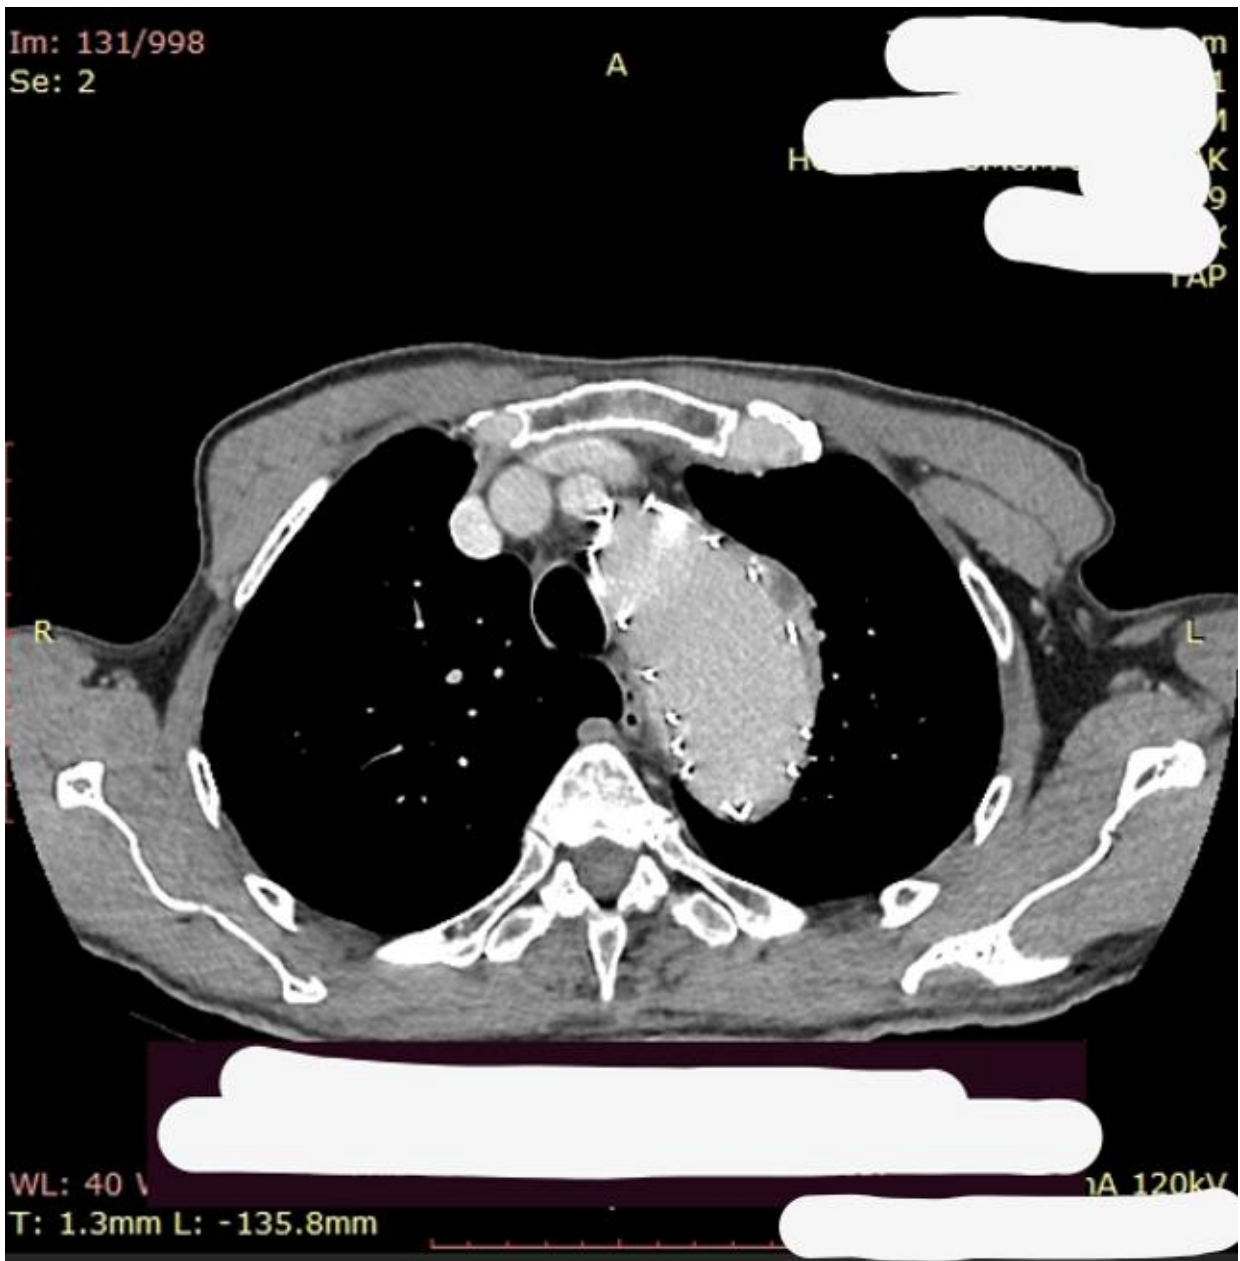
Axial view of CTA post TEVAR.
